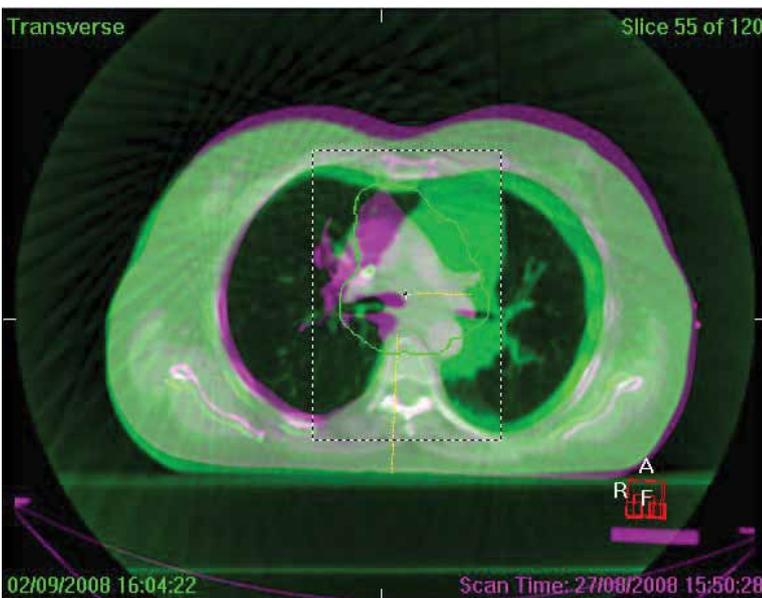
Elekta Synergy® VolumeView™ – fraction 3 at level of carina showing bony anatomy and patient outline match is acceptable, but soft tissue anatomy does not match, (RT planning scan purple, CBCT green).
